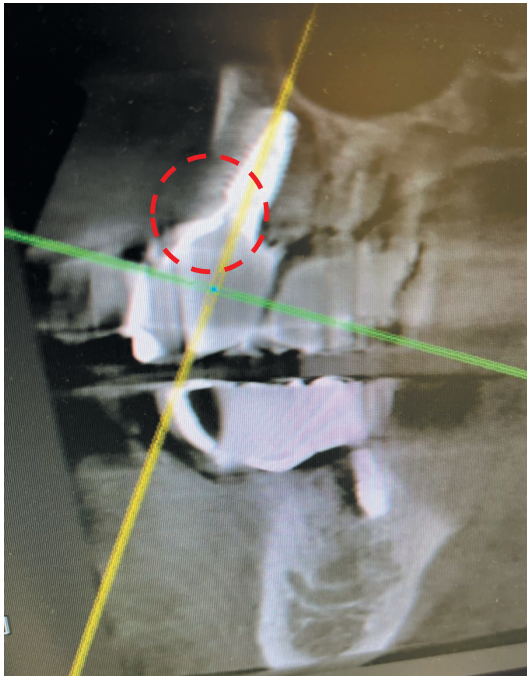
X-ray image, taken two months after Mg wire placement, where broken red circle indicates the area where Mg wire network was placed.
